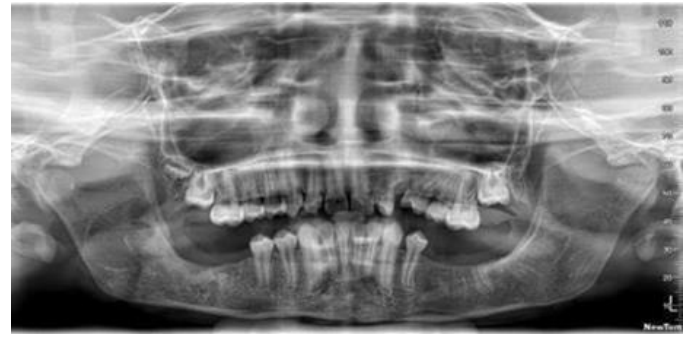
Post-operative radiograph after a span of 1 year
